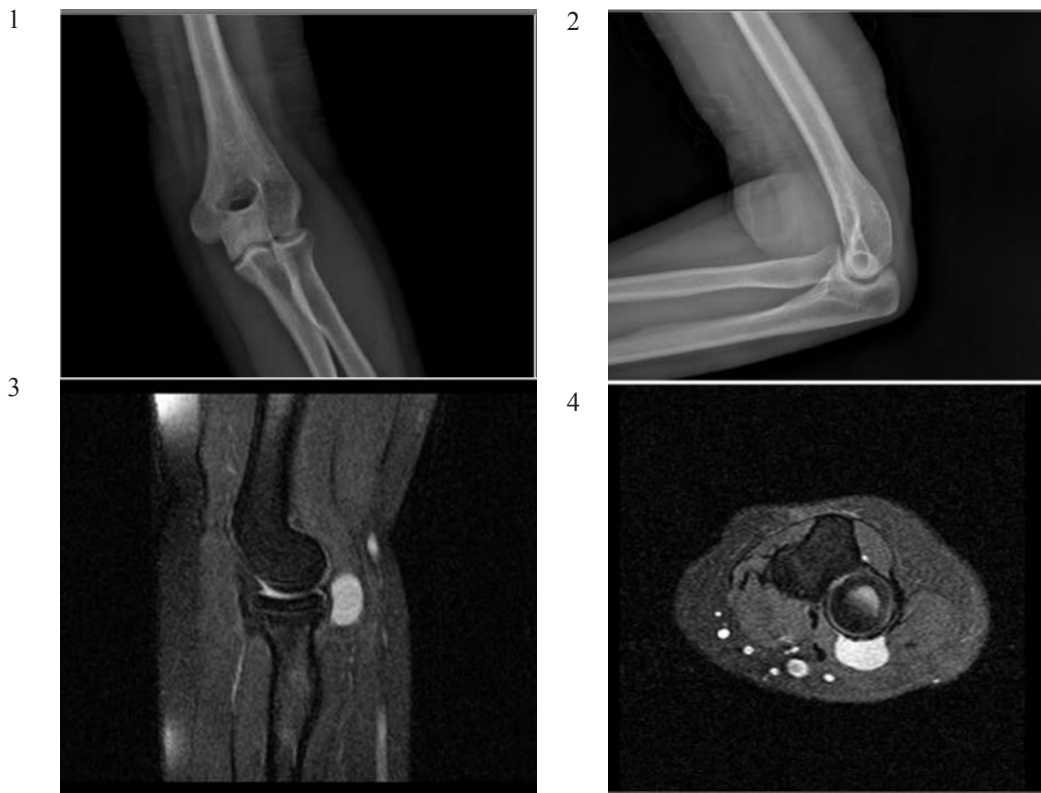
x-ray 1. AP; 2. Lateral; and MRI 3. Sagittal T2 weighted; 4. Axial T2 weighted of elbow
